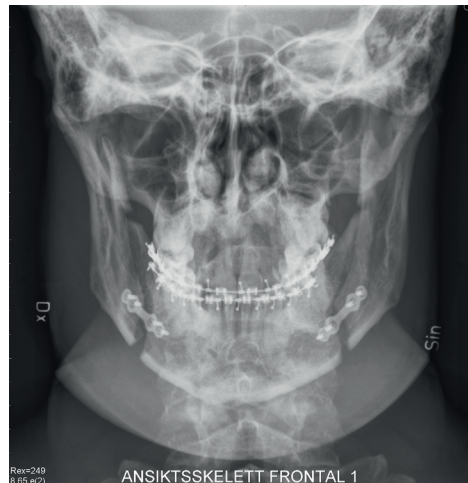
Frontal radiograph obtained the day after surgery and before discharge from the hospital.
